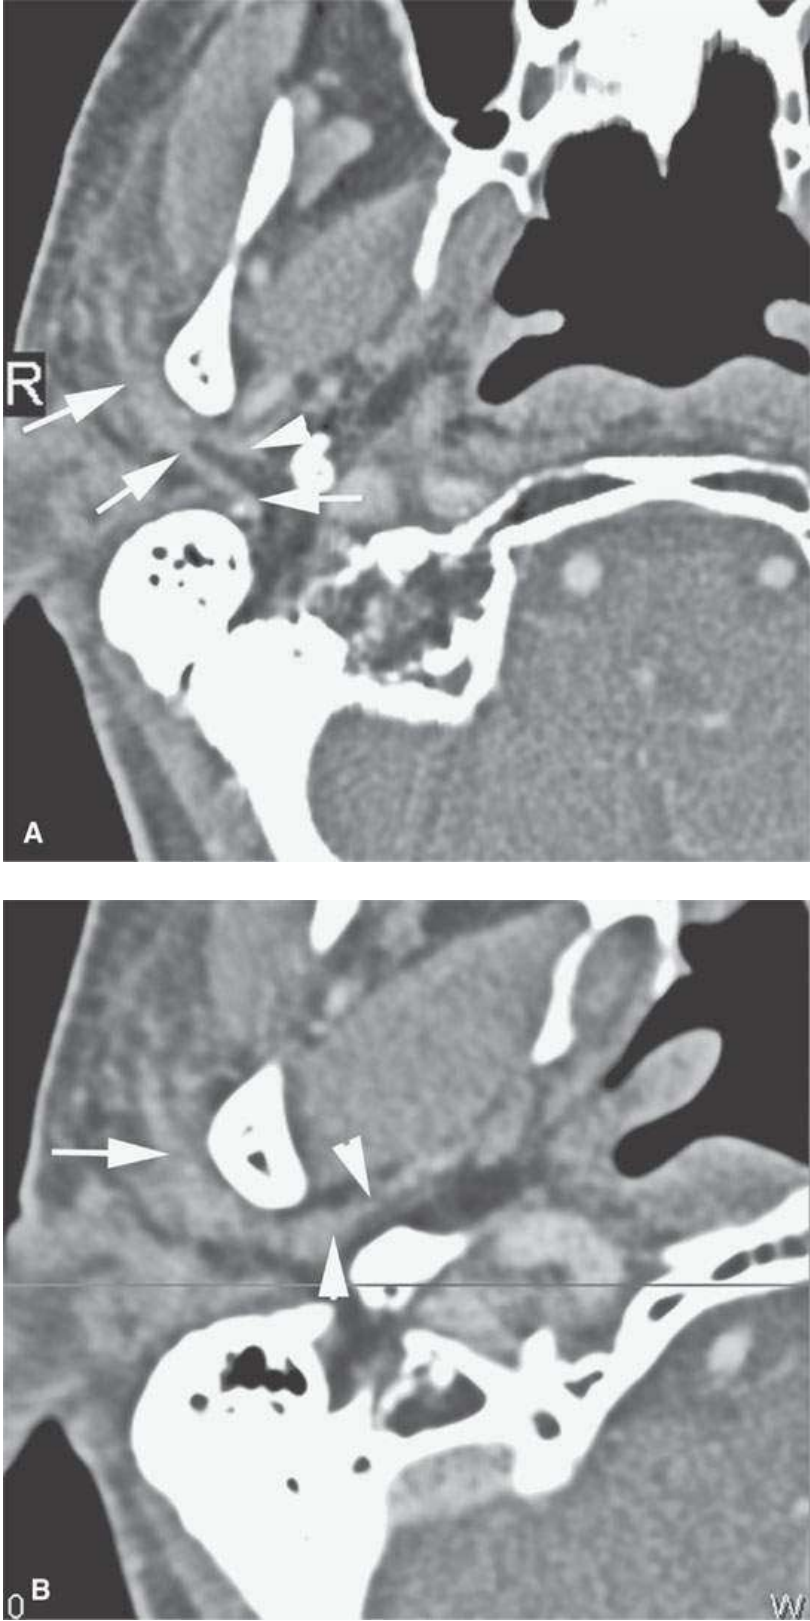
Contrast-enhanced computed tomography in a patient thought to have a much localized superficial failure in the skin of the periauricular region at the original site of the squamous cell skin carcinoma; however, the patient had worsening right otalgia. Deeply recurrent tumor tracks along the facial nerve (arrows in A and B) to the auriculotemporal nerve junction with V3 (arrowheads in A and B).
